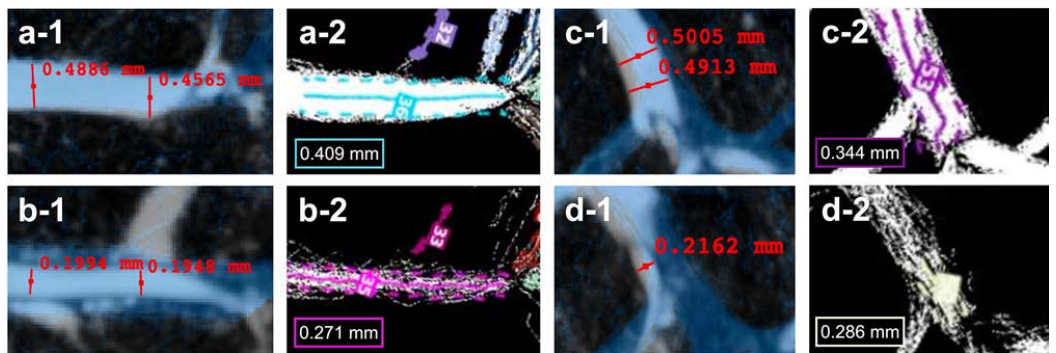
Examples of vessel diameter measurements. (a-1) Arcuate vein in the μ CT with blue super-resolution ultrasound image overlap, shows diameter measurements of 0.489 mm and 0.457 mm. (a-2) Corresponding vessel in the microbubble track map showing a mean diameter, estimated around the turquoise centerline, of 0.409 mm. (b-1) shows the arcuate artery paired with (a-1) with diameter measurements of 0.199 mm and 0.195 mm. (b-2) Corresponding vessel in the microbubble track map showing a mean diameter estimation of 0.271 mm. (c-1) Another example of an arcuate vein in the μ CT with diameter measurements of 0.501 mm and 0.491 mm. (c-2) Corresponding microbubble track map with a mean diameter estimation of 0.344 mm. (d-1) Paired arcuate artery in the μ CT with diameter measurements of 0.216 mm. (d-2) Corresponding artery in the microbubble track map with estimated diameter of 0.286 mm.
